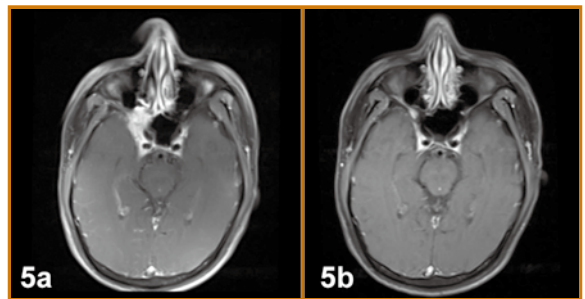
Effect of neoadjuvant CT on tumour invading right inferior orbital fissure and cavernous sinus (a) Pre-CT MRI (b) Post-CT MRI
